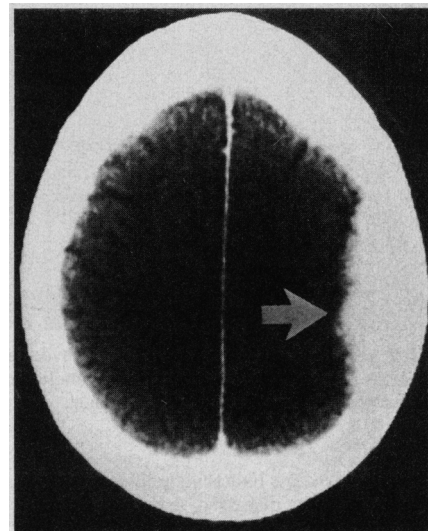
Computed tomographic scan with contrast enhancement showing enhancing lesion (arrow) over left parietal region.
